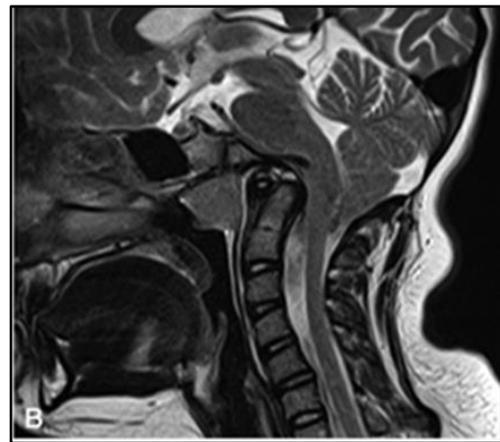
Sagittal T2 weighted MRI demonstrating severe brainstem deformity as a result of a kyphotic clivo-axial angle.
